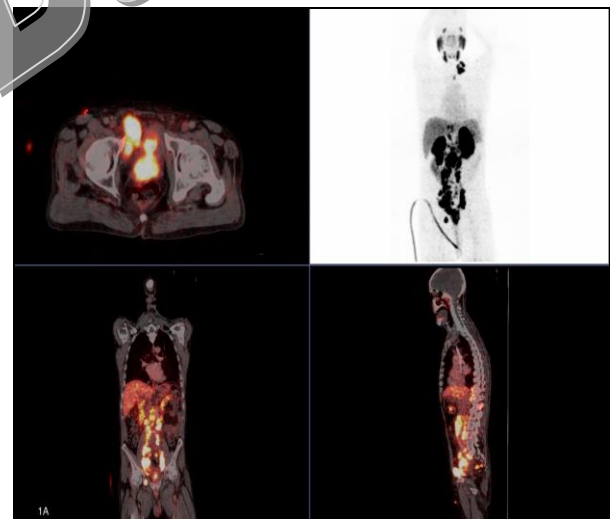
^{68}Ga -PSMA PET-CT findings related to ^{68}Ga -PSMA ligand uptake showing: malignant lesion in the prostate gland, seminal vesicle involvement, lymph node invasion and bone metastases in an 82-year old prostate cancer patient with prostate SUV max of 21.7, Gleason score of 9 and PSA level of 108 ng/ml.
